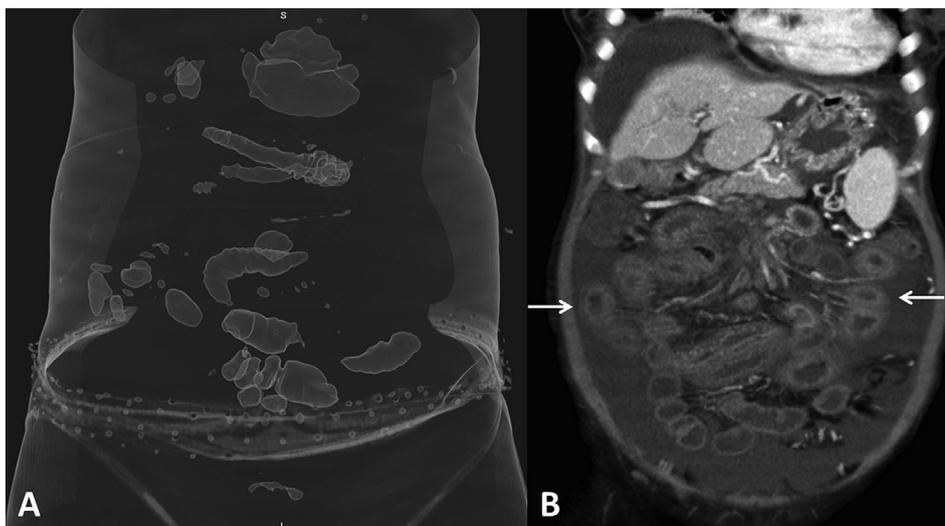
A. 3D TTP transparent wall CT reconstruction shows entire small bowel dilatation in a dead patient. B. Multiplanar reconstruction on the coronal plane shows the occlusion of the superior mesenteric artery (arrow).
